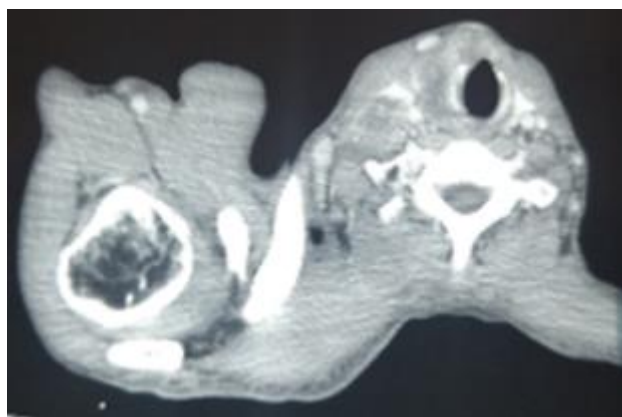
Cervico-thoracic CT scan axial plan
